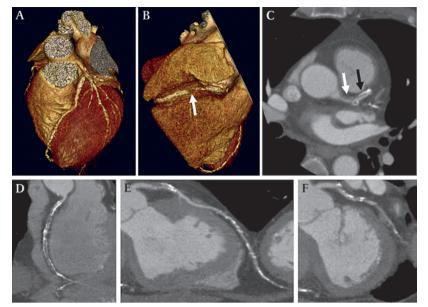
The 55-year-old patient discussed in figure 9 underwent 64 slice multislice computed tomography. In panels A and B, three dimensional volume rendered reconstructions are provided, showing extensive atherosclerosis, as well as an indication of a high grade lesion in the right coronary artery (panel B, arrow). In panel C, an axial image, which is used for evaluation, is shown. In the left main, non-calcified plaque can be observed, resulting in significant stenosis (white arrow). In the proximal left anterior descending artery, extensive calcifications are visible (black arrow). The presence of extensive atherosclerosis, resulting in multiple significant lesions, can also be observed on the curved multiplanar reconstructions of respectively the right coronary artery (panel D), left anterior descending artery (panel E), and left circumflex artery (panel F). Findings were confirmed during conventional coronary angiography and the patient subsequently underwent coronary bypass grafting.
